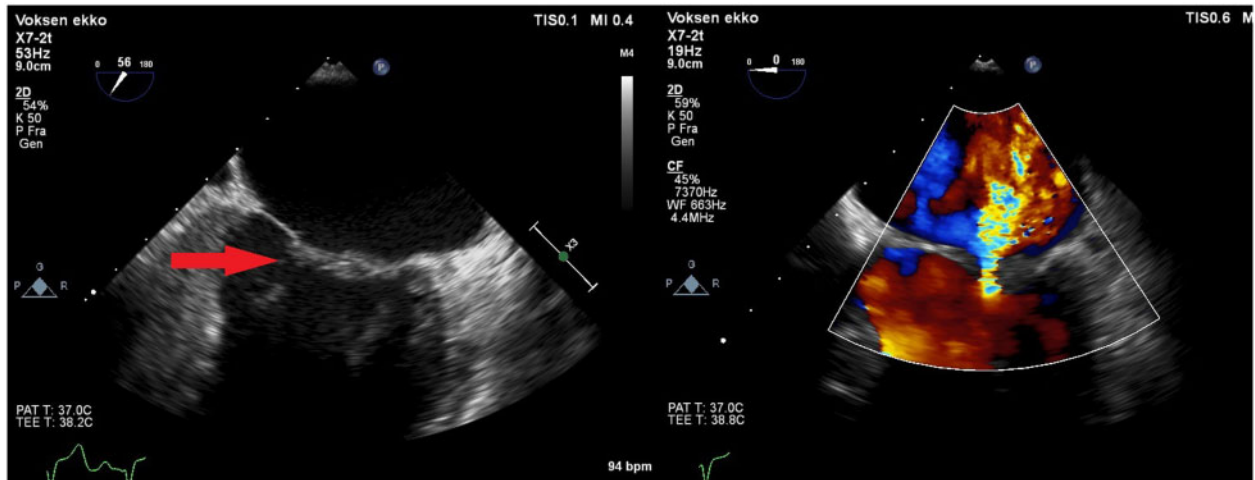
Transoesophageal echocardiogram of the mitral valve at follow-up visit 3 months later, after rituximab treatment. Images show regression in the valve lesions and development of severe mitral regurgitation due to fibrotic changes of the valve.
